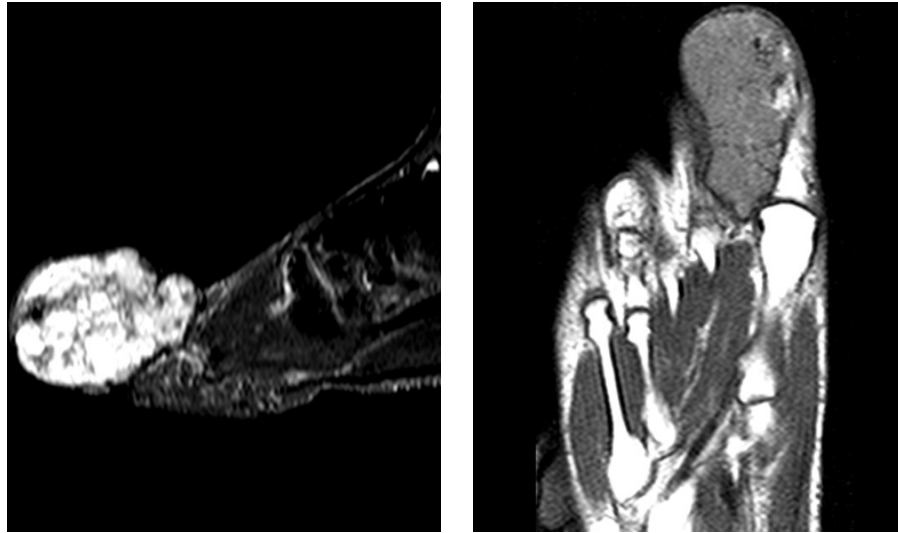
MRI of the lesion shows T1-weighted images lesion is isointense with muscles and T2-weighted images hyperintense with muscles
